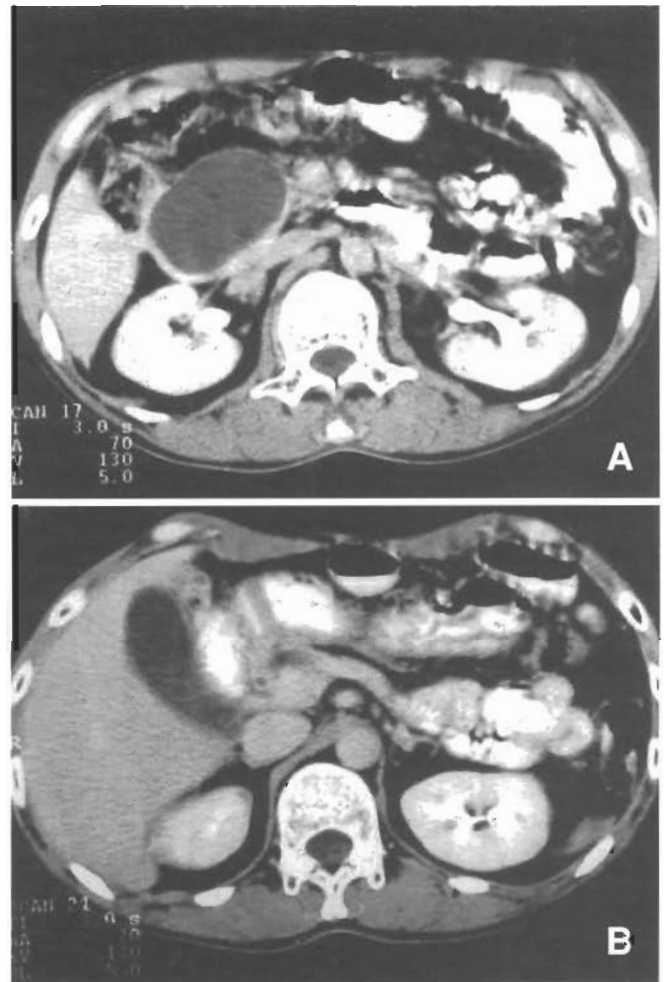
A. Initial CT revealed a 4x6 cm of pseudocyst at pancreatic head area with thin wall of cyst was observed.
